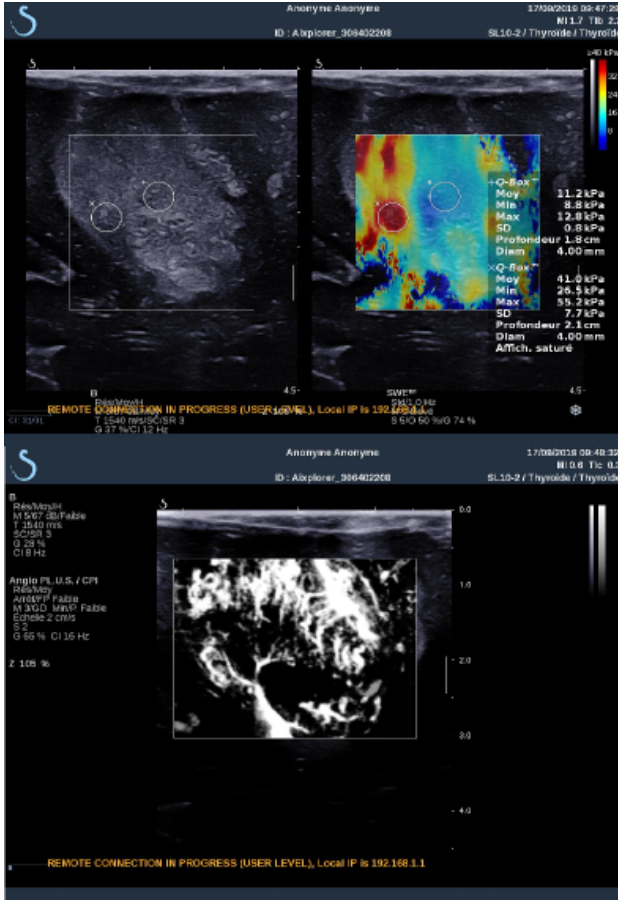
B-mode, Young modulus and Power Doppler AngioPlus images of a heterogeneous cerebral glioma obtained *in vivo* with the Aixplorer commercial mode
